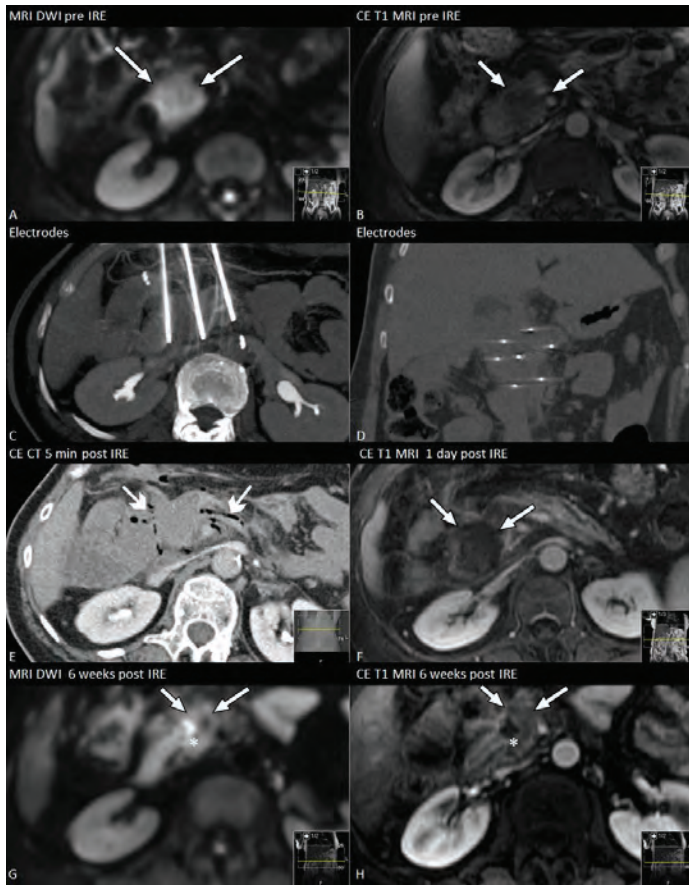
Radiologic appearance of the pancreatic tumor before, during and after IRE. (A) MRI pre-IRE showing hyperintensity of the tumor on diffusion-weighted imaging (DWIb800), and (B) hypoattenuation compared to normal pancreatic tissue on ceMRI (T1-weighted with fat suppression). Electrode configuration in the (C) axial and (D) coronal plane. (E) CeCT showing gas pockets immediately after IRE (arrow-head). (F) T1-weighted CeMRI demonstrating loss of tumor enhancement 1 day post-IRE. (G, H) DWIb800 and T1-ceMRI six weeks after IRE reveal no residual diffusion restriction and involution of the ablation zone. A typical DWIb800 hyperintense area, typical for a fluid collection presumably represents a small abscess (*).
